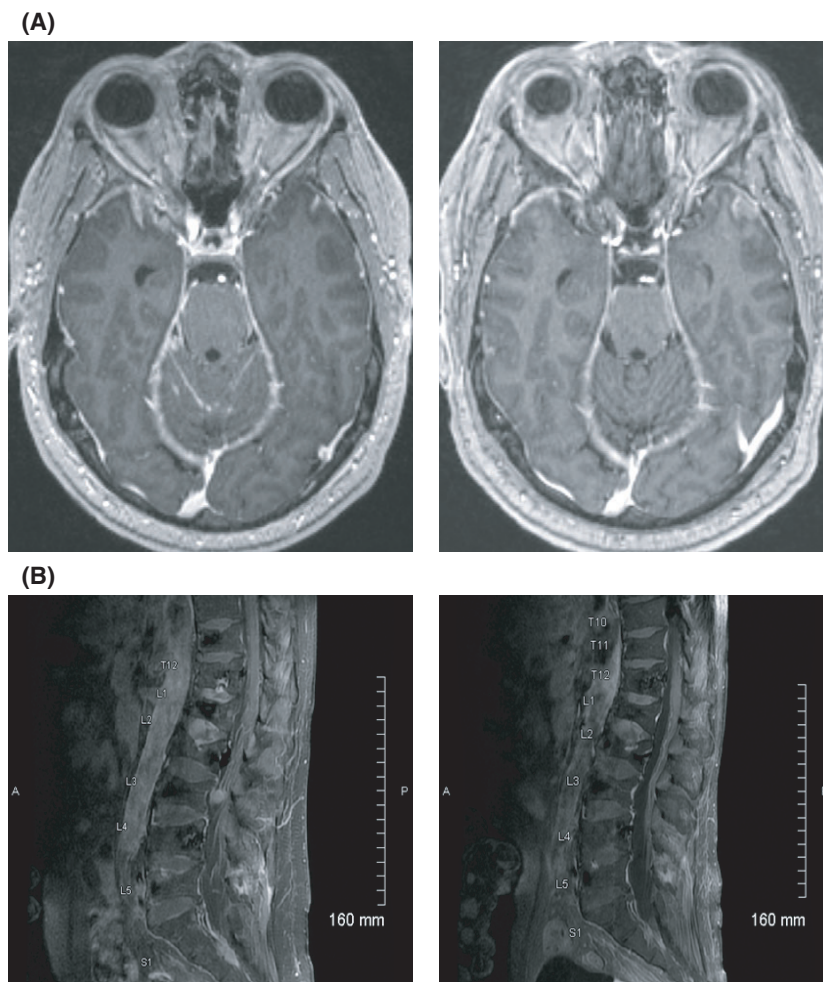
Magnetic resonance imaging findings before (left images) and 2 months after marizomib therapy (right images) in (A) Case 1 (head) and (B) Case 2 (lumbar spine).
